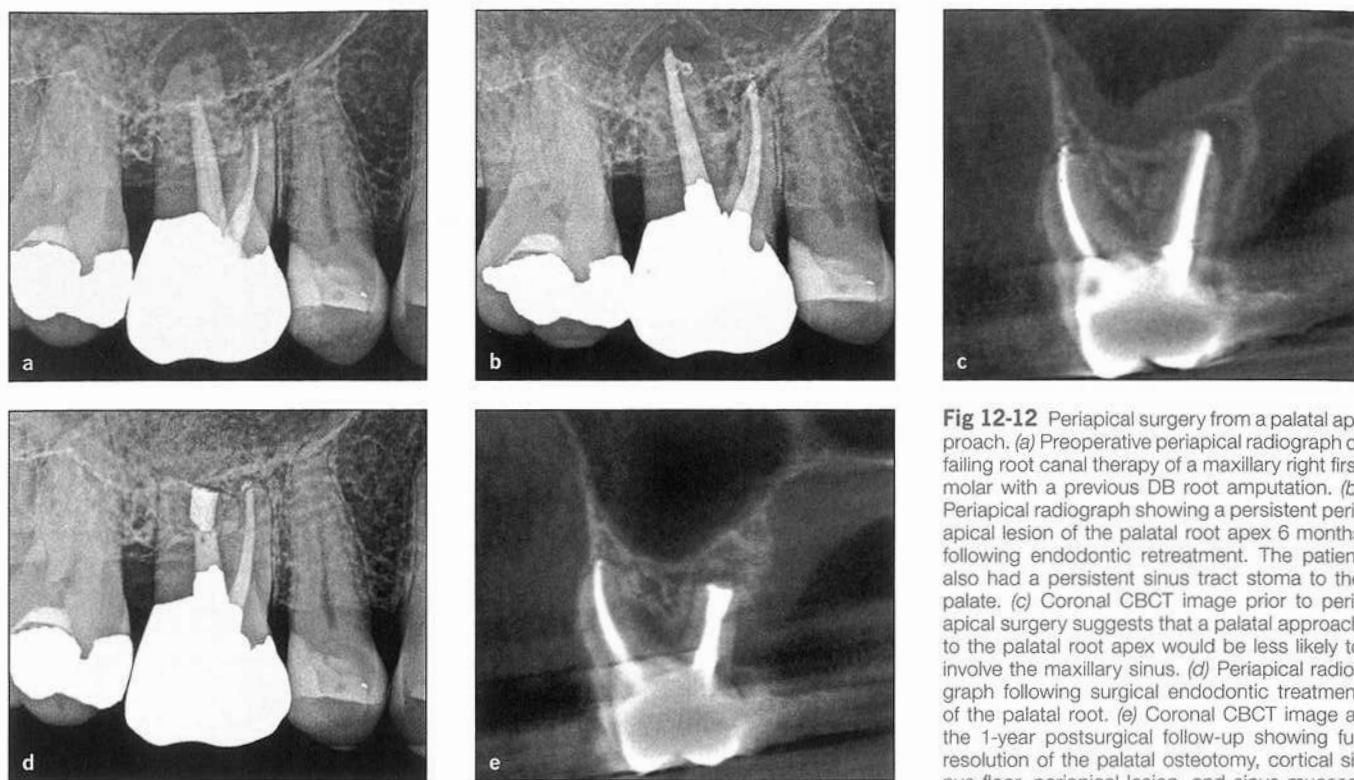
Periapical surgery from a palatal approach. (a) Preoperative periapical radiograph of failing root canal therapy of a maxillary right first molar with a previous DB root amputation. (b) Periapical radiograph showing a persistent periapical lesion of the palatal root apex 6 months following endodontic retreatment. The patient also had a persistent sinus tract stoma to the palate. (c) Coronal CBCT image prior to periapical surgery suggests that a palatal approach to the palatal root apex would be less likely to involve the maxillary sinus. (d) Periapical radiograph following surgical endodontic treatment of the palatal root. (e) Coronal CBCT image at the 1-year postsurgical follow-up showing full resolution of the palatal osteotomy, cortical sinus floor, periapical lesion, and sinus mucosal edema.
